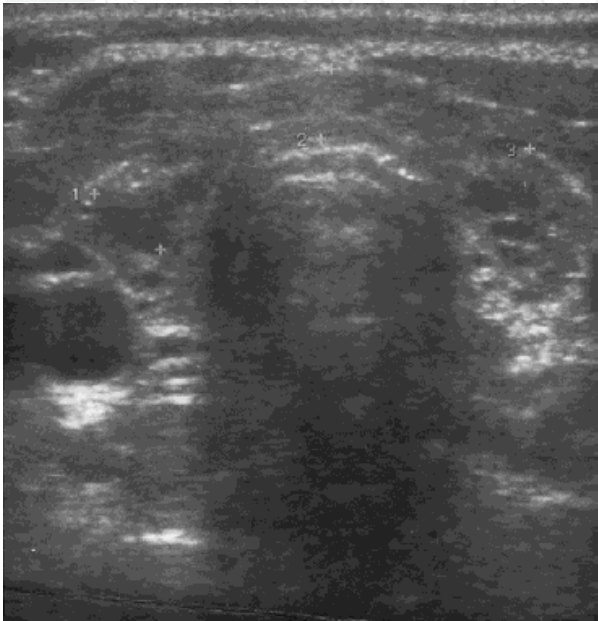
Ultrasound trasphersal scan of the thyroid in atrophic CAT.
